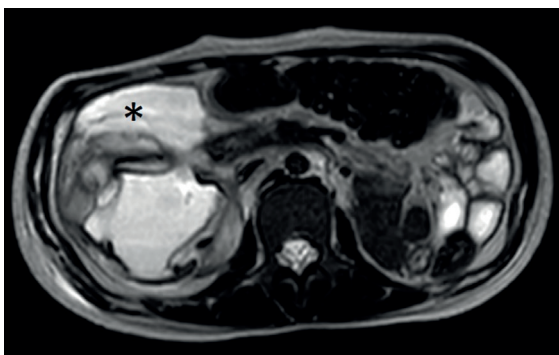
Follow-up abdominopelvic magnetic resonance imaging demonstrating a significant increase in the retroperitoneal fluid collection (asterisk).
